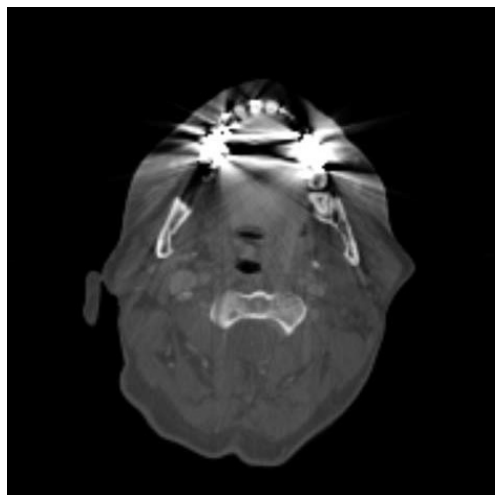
Image provided by Abdoli *et al.*: Metal artifact reduction in CT-based PET attenuation correction
